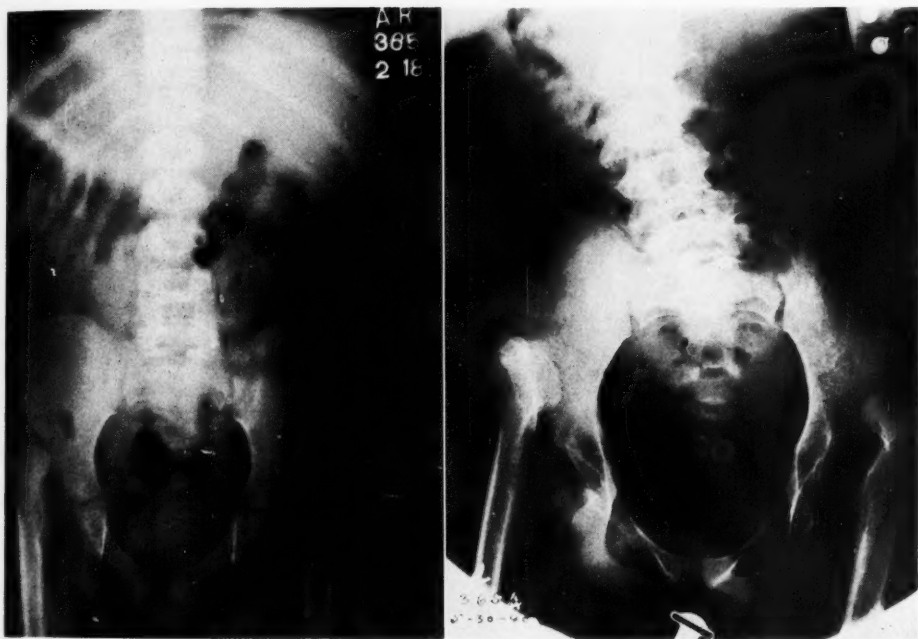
Roentgenograms showing bilateral dislocation of hips and delayed appearance of the epiphyses. Note development of kyphoscoliosis.
